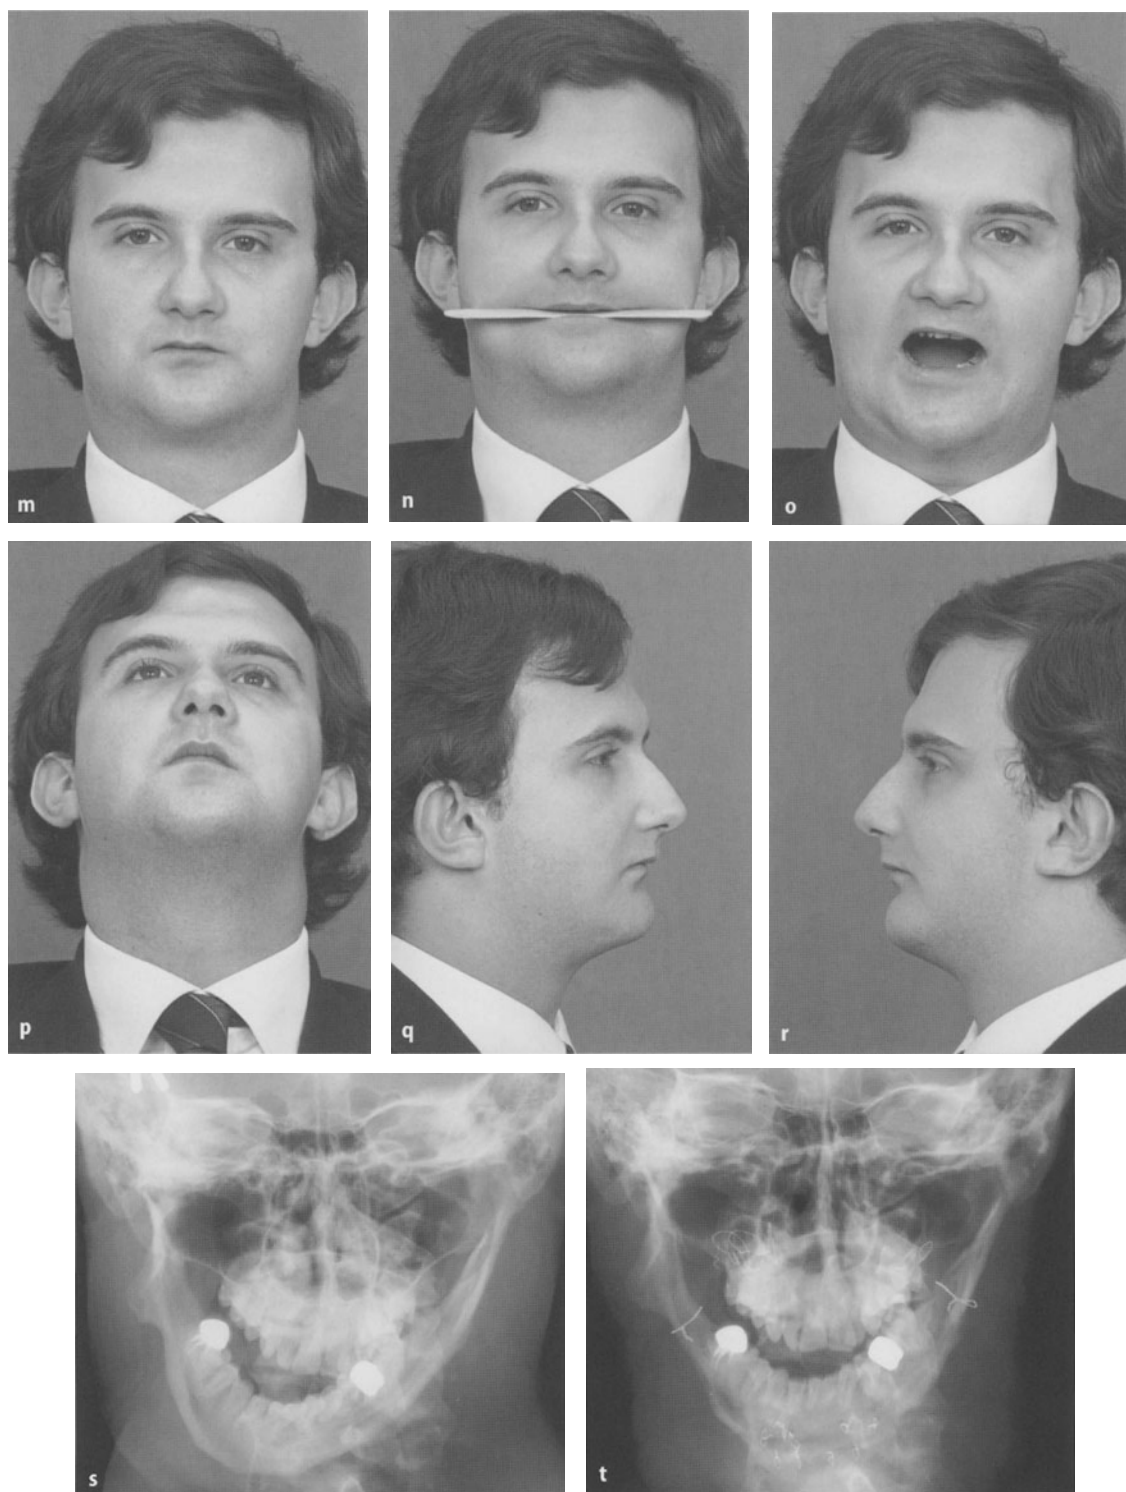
Unilateral hemimandibular hypoplasia after unilateral ankylosis due to purulent otitis media and release of the ankylosis at the age of 11 years. m-r The final result of the two-stage corrective surgery with an absolutely symmetrical facial appearance. s,t The two p.a. radiographs of the mandible disclose the pre- and postoperative shapes of the mandible
